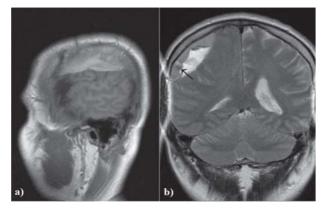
a) The most lateral sagittal view of the T1-weighted MRI shows the proximity of the frontobasal parts of the CSDH and the arachnoid cyst; b)T2-weighted MRI coronal view- the arrow points to a small heterointense zone inside the heterointense zones representing the CSDH.
